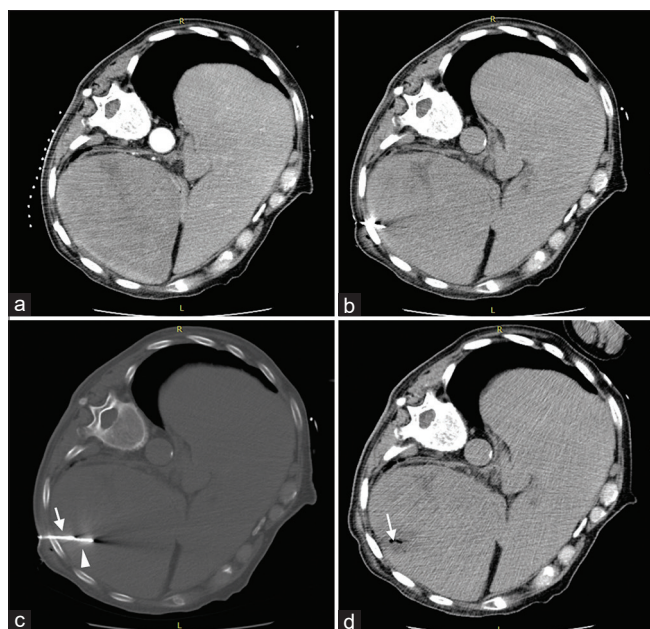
An 81-year-old male with abdominal pain and poor appetite. (a) Computed tomography image of abdomen showed enlarged spleen with multiple masses. (b) Computed tomography-guided core-needle biopsy of the splenic mass was performed. (c) Computed tomography-guided microwave ablation (arrowhead) was performed following biopsy (arrow). (d) Computed tomography image after splenic biopsy and microwave ablation (arrow)
